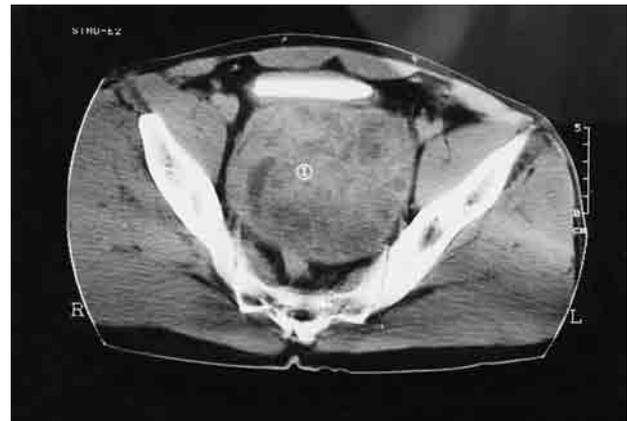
CT scan demonstrated a huge intravesical mass, occupying most of the bladder.
